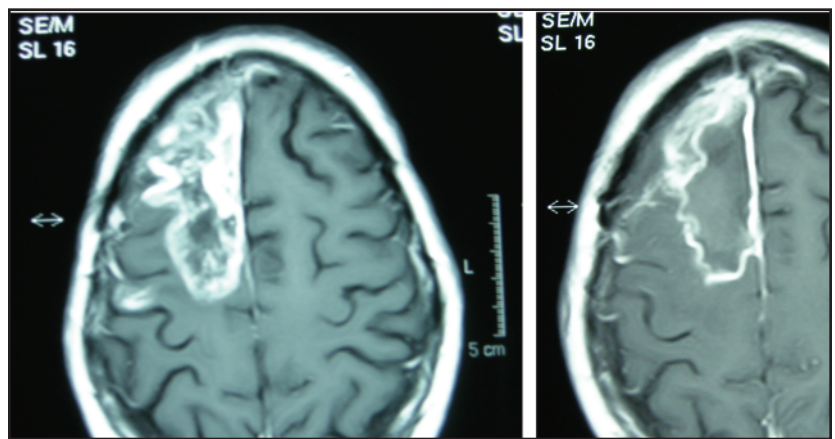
(A.) Baseline MRI. (B.) MRI after eight weekly doses of cetuximab.
